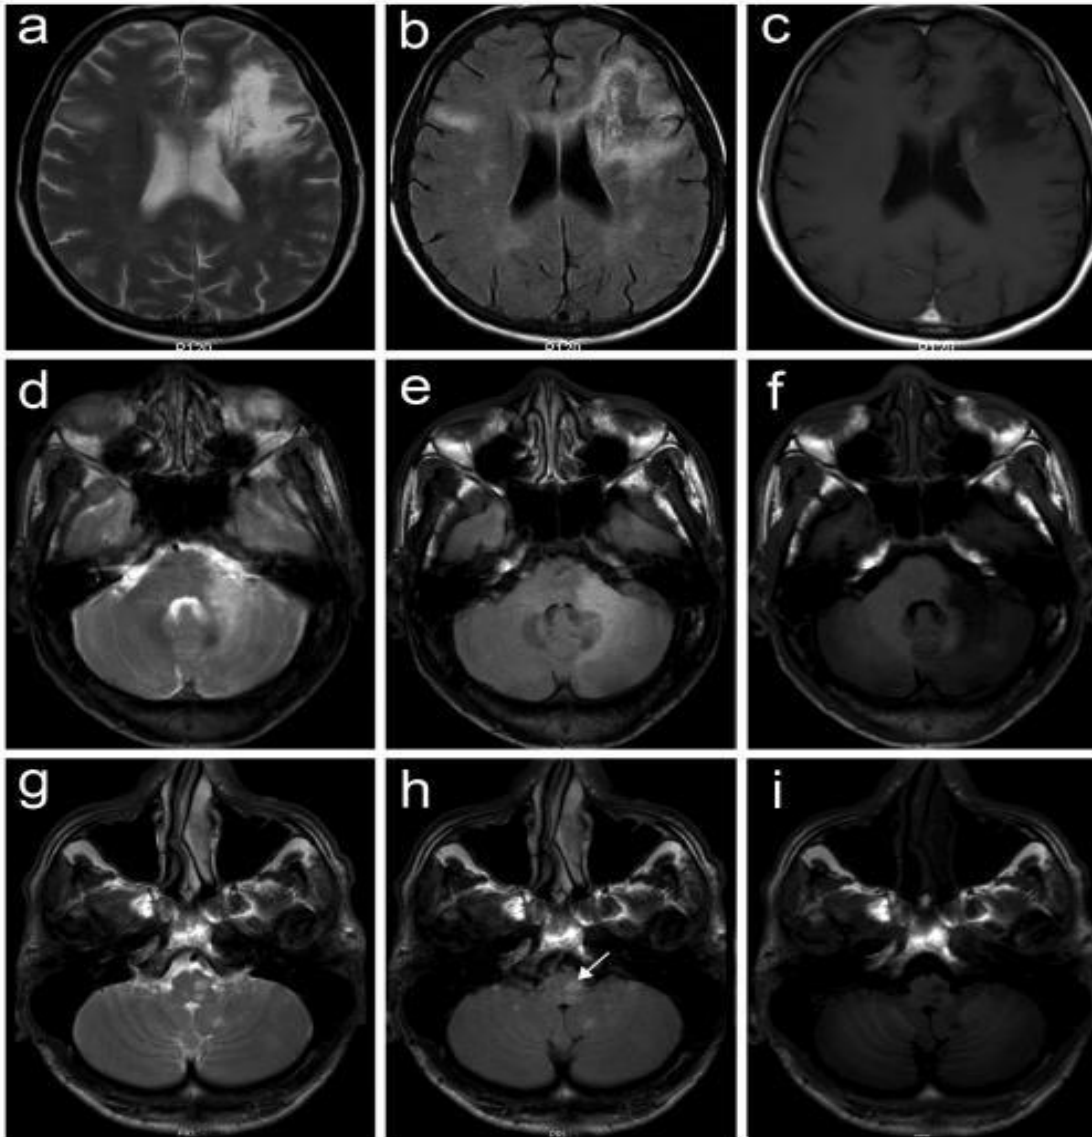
MRI appearance of active PML lesions (a,d,g, T2; b,e,h, FLAIR; c,f,,i, Gd-T1 axial sequences). In all cases, the lesions are hyperintense (white) in T2 and FLAIR sequences and hypointense (dark) in T1 sequences, showing no enhancement after Gd administration. a-c. Hemispheric localization: large white matter signal alteration in the left frontal lobe extending to the corpus callosum and left deep white matter, with additional FLAIR/T2 high-intensity signal alterations in the right frontal and temporal lobes. d-f. Cerebellar localization: large signal alterations of the left middle cerebellar peduncle and hemisphere. g-i. Brain stem localization: focal signal alterations of the left bulb (arrow) and cerebellar hemispheres.
